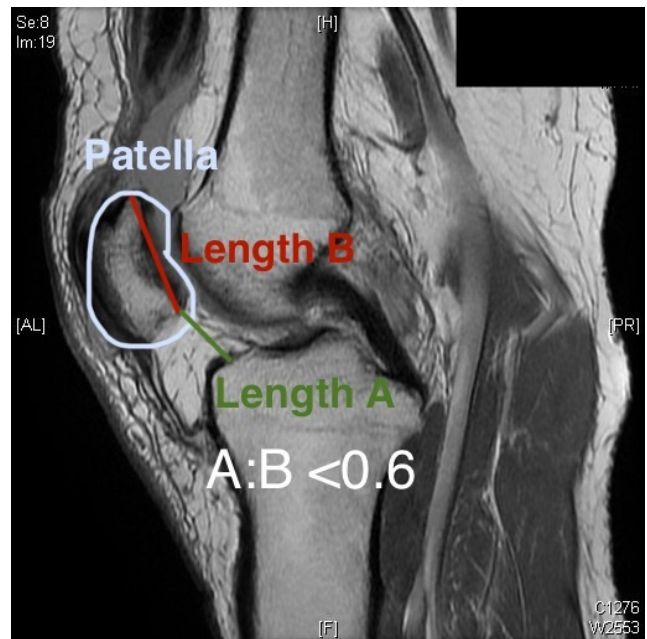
MRI Scan of Patella Baja depicting a CDI ratio less than 0.6
